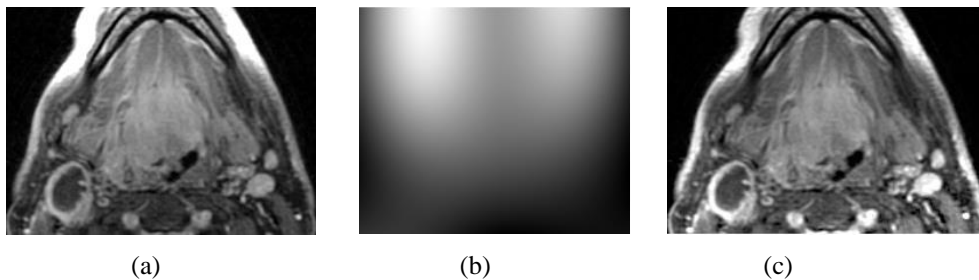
(a) MRI slice (b) estimated bias field for Fig 5.1(a) (c) IIH reduced slice (roughly obtained by dividing Fig. 5.1(a) by Fig. 5.1(b)) [11] © 2014 IEEE.
